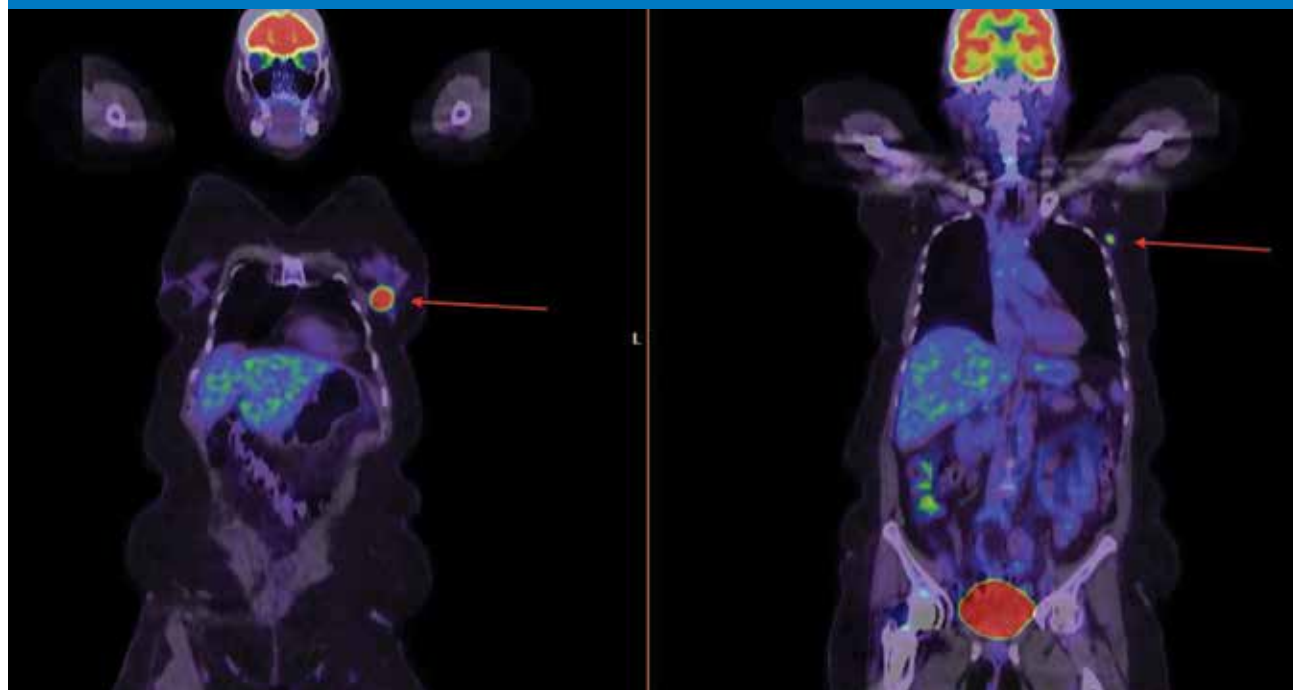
From left to right, PET/CT demonstrating FDG avid left breast cancer (indicated with red arrow) and an FDG avid left axillary metastatic lymph node (indicated with red arrow).
